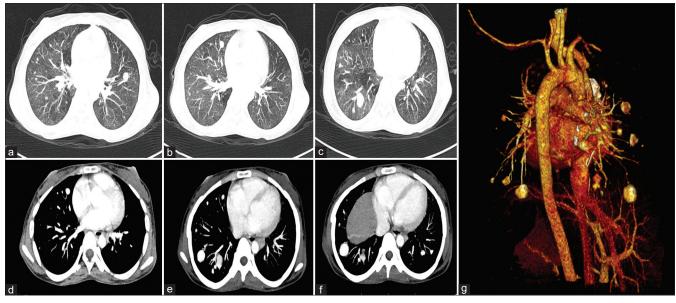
Axial computed tomography angiography images after 6 months in lung window (a-c) shows new rounded nodules communicating with segmental branches of pulmonary artery in bilateral lungs. In the mediastinal window (d-f) the nodules fill with contrast. Few miliary nodules persist in the background. No consolidations or cavitation's are seen. 3D Volume Rendered Image shows the aneurysms communicating with peripheral branches of the pulmonary artery (g).
